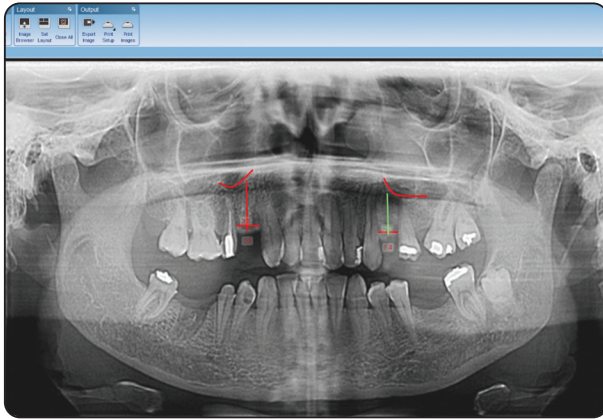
Showing Computer-guided length measuring on panoramic radiograph.
